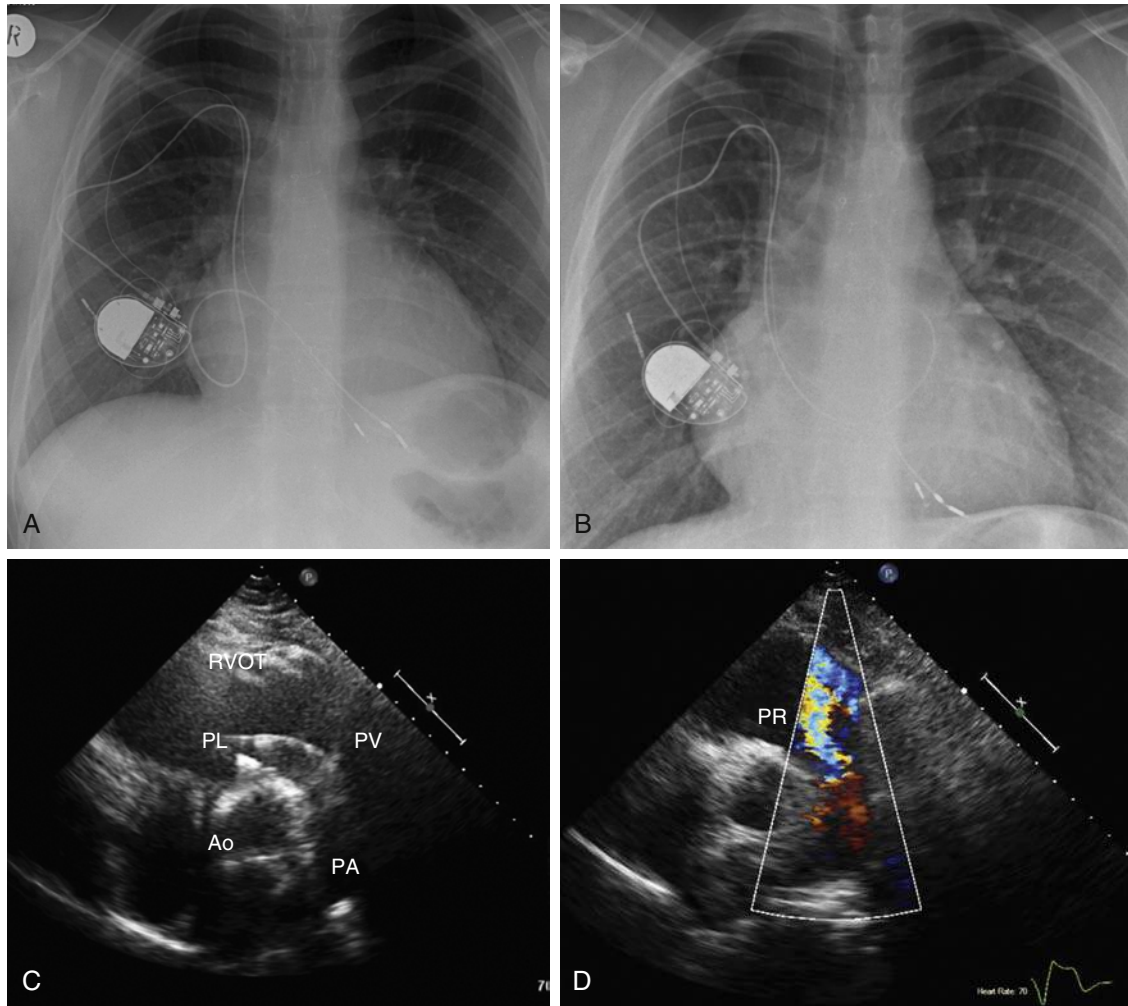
A to D, A 26-year-old woman was referred for lead extraction due to valvular regurgitation believed to be a consequence of a pacemaker lead. As a child, she had an atrioventricular (AV) septal defect that was successfully repaired, but unfortunately the surgery was complicated by post-operative complete heart block. A single-chamber VVI pacemaker was implanted, which needed multiple changes as she grew older. A and B, A loop in the PL was left in the right atrium to account for growth in her teenage years, but it was a little too large and serial chest X-rays showed that the loop was mobile and able to prolapse into the right ventricle. (One abandoned lead is also evident on the chest X-rays). Transthoracic echocardiography confirmed the loop not only reached the right ventricular outflow tract (RVOT), C, but the loop also intermittently prolapsed through the pulmonic valve, causing pulmonic regurgitation that became increasingly severe over time. D, An aliased jet in the RVOT during diastole, indicative of pulmonary regurgitation (PR). Moderate tricuspid regurgitation was also present and probably at least partly lead related (not shown). Ao, Aortic valve; PA, pulmonary artery; PL, pacing lead; PV, pulmonic valve; PR, eccentric jet of pulmonary regurgitation; RVOT, right ventricular outflow tract.
